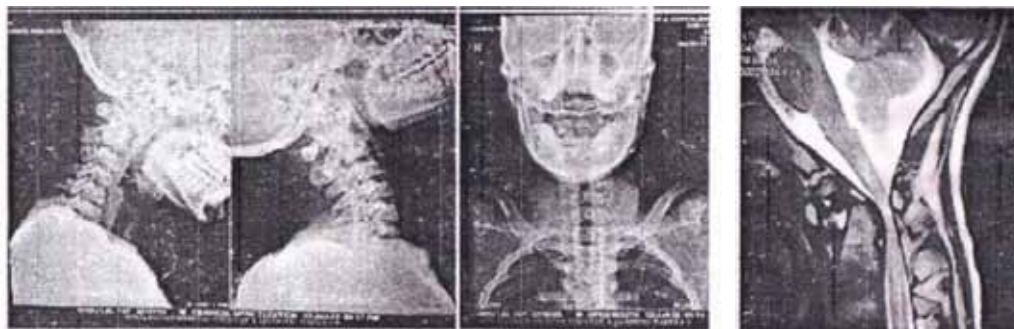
showing preoperative X-rays of Cervical spine AP, Lateral and open mouth view with 1 MRI image
